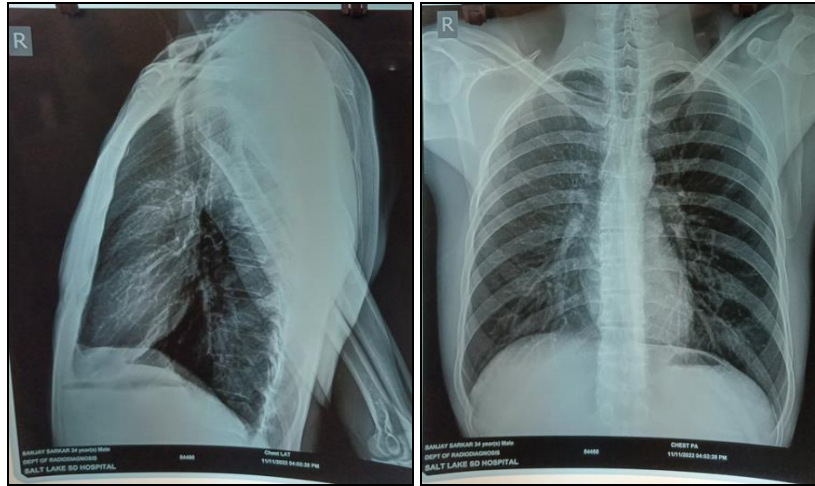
Before Treatment (X-Ray Plates) (1/11/22)
